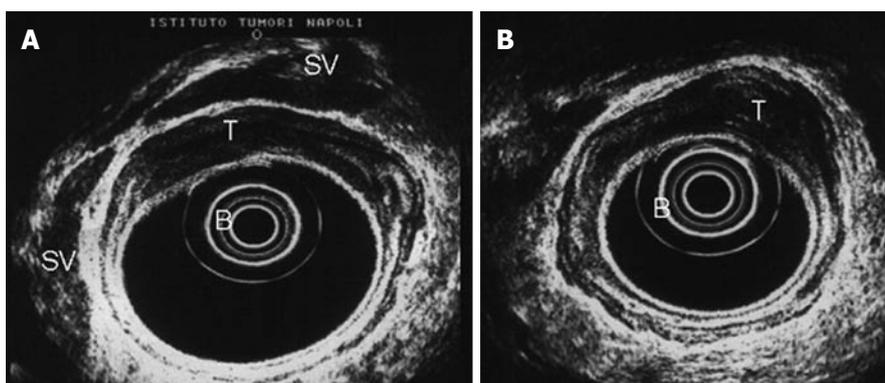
Stage T2 rectal cancer: Ultrasonographic view. The tumor infiltrated the entire wall, without invading the smooth outer margin of the muscularis propria (fourth layer). Endoscopic ultrasound with radial array transducer UM 20 (7.5-12 MHz). B: Balloon; T: Tumor; SV: Seminal vesicles.
